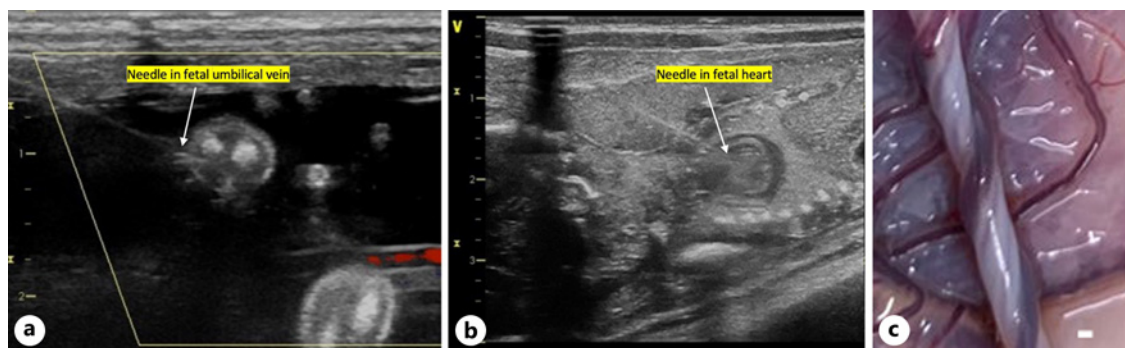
Ultrasound images of NP injection into NHP umbilical vein (a) and fetal right ventricle (b). c Image of the spiraling umbilical vein (white bar = 1 mm).
